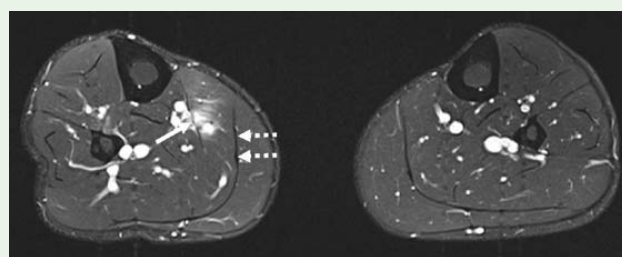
Bilateral axial T2-FS calf MRI 3 weeks later, following acute right medial calf strain during a game. Image at the same level as Figure 1a showing a small tear of the right medial soleus intra-muscular aponeurosis (arrow). The plantaris tendon and adjacent gastrocnemius and soleus aponeuroses (dotted arrows) appear thickened bilaterally. The player underwent calf adhesiolysis for recurrent calf tightness on 2 occasions with initial improvement in knee to wall measurements from 12 to 14cm. Return to full training was affected by unrelated injury.
